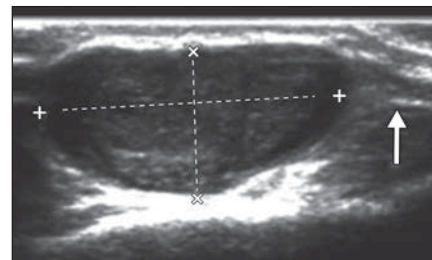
27-year-old man with schwannoma of ankle. Gray-scale ultrasound image shows echogenic mass (calipers) with increased through-transmission. Entering or exiting nerve sign (arrow) confirms origin from peripheral nerve.
